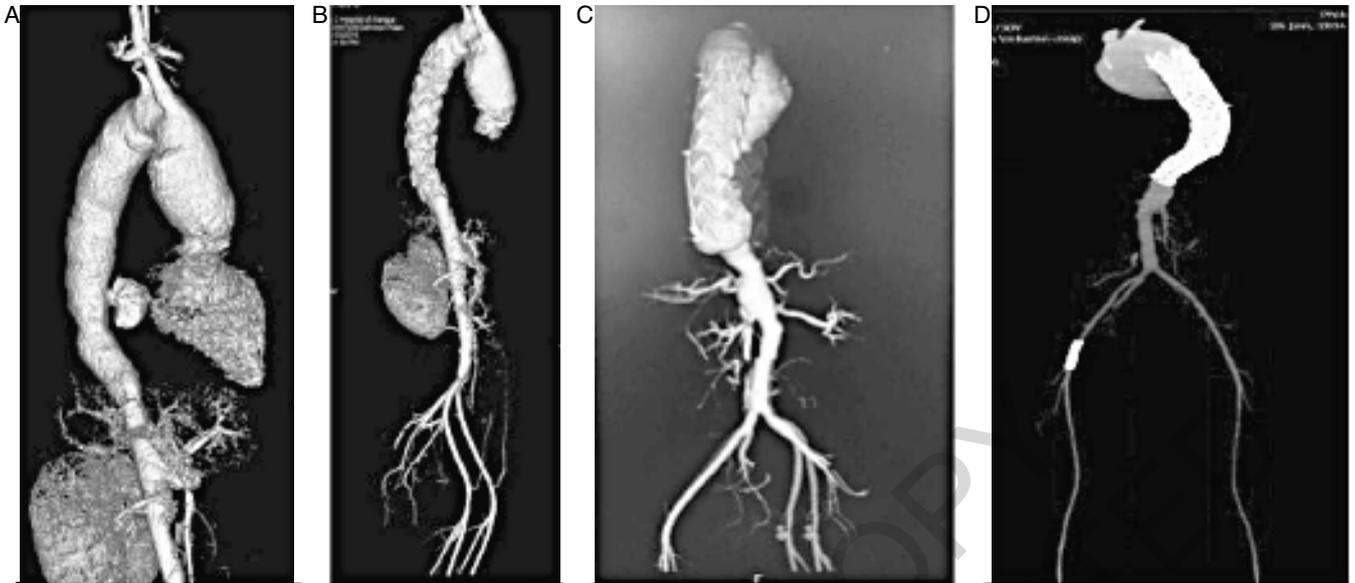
Case 1 CTA(A) CTA revealed the pseudoaneurysm of the thoracic aorta. (B) The first operation after the endovascular procedure (C). CTA revealed the pseudoaneurysm at the original distal end of the stent-graft, and at the original incision in the femoral artery. (D) The second operation after the endovascular procedure is shown.
